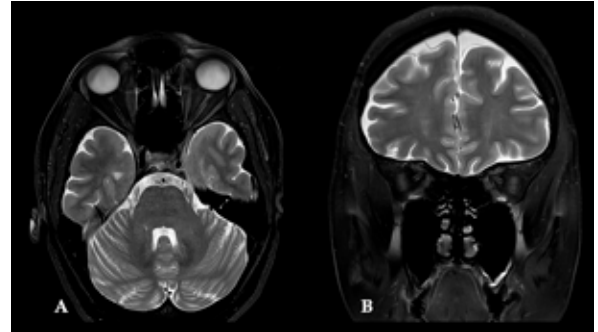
Chronic bilateral optic nerve atrophy in an AQP4(+)/NMOSD 45-year-old female. The patient had a history of recurrent bilateral optic neuritis episodes over the last 30 years, resulting in bilateral blindness. Axial (A) and coronal (B) T2-weighted images depicting bilateral optic nerve atrophy.
